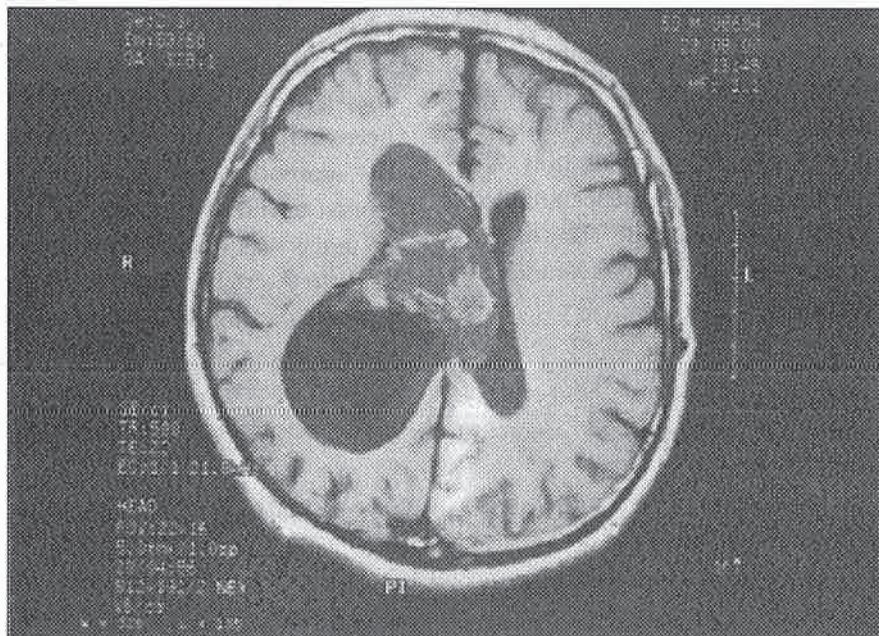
On non enhanced T1-weighted axial spin echo (SE) MR image, the cystic areas of the lesion are hyperintense than cerebrospinal fluid and the solid portions are iso-hyperintense compared to cerebral gray matter.
